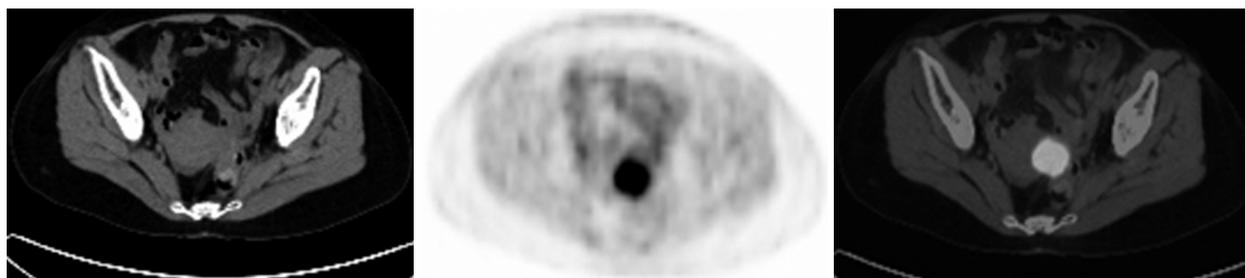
PET/CT imaging showing local recurrent rectal carcinoma in a 49-year-old female postoperative rectal cancer patient. CT scan did not find definite recurrence signs. PET imaging detected hyper-intensive radioactivity by the left side of uterus. The SUV_{max} was 7.5 and the T/N was 9.4. Combined PET/CT imaging indicated elevated ¹⁸F-DG uptake of the anastomosis. The reoperation confirmed a recurrent tubular adenocarcinoma of the rectum.
